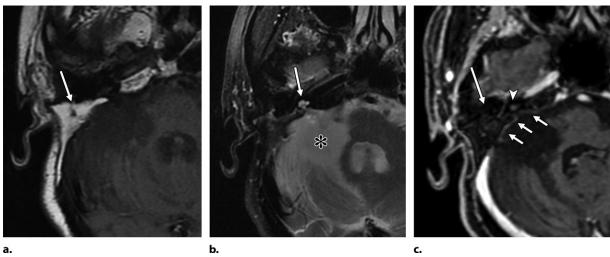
Right translabyrinthine approach with fat graft placement. (a) Axial T1-weighted MR image shows the typical high signal intensity of the fat graft (arrow). (b) Axial T2-weighted fat-suppressed MR image shows the preserved contours of the cochlea (arrow) and absence of the vestibule and semicircular canals. There is also encephalomalacia of the right cerebellar hemisphere due to traction of the parenchyma (*). (c) Axial contrast-enhanced T1-weighted fat-suppressed MR image shows the fat-graft saturation (long arrow) and expected linear enhancement along the periphery of the fat graft and IAC walls (short arrows). Note the faint cochlear enhancement (arrowhead), which is probably related to fenestration of the labyrinth.
